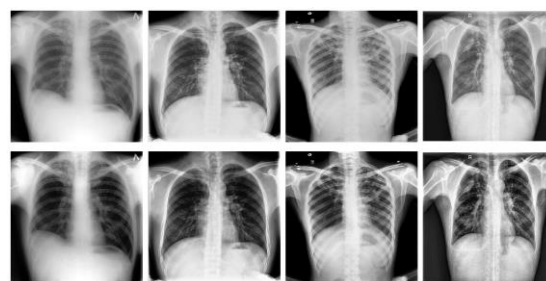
Examples of chest X-rays (above) and their CLAHE-processed versions (below)
